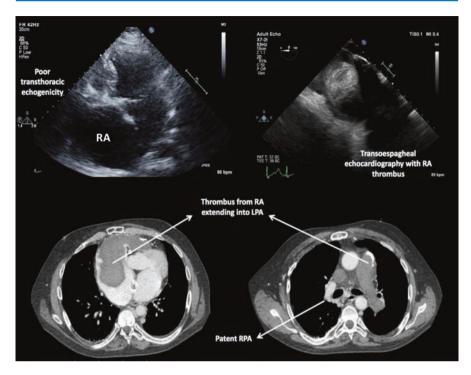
Echo (upper panels) and computed tomography (lower panels) imaging a giant thrombus in RA (upper right panel) extending into LPA. RPA was free of thrombus (*RA* right atrium, *LPA* left pulmonary artery, *RPA* right pulmonary artery)
